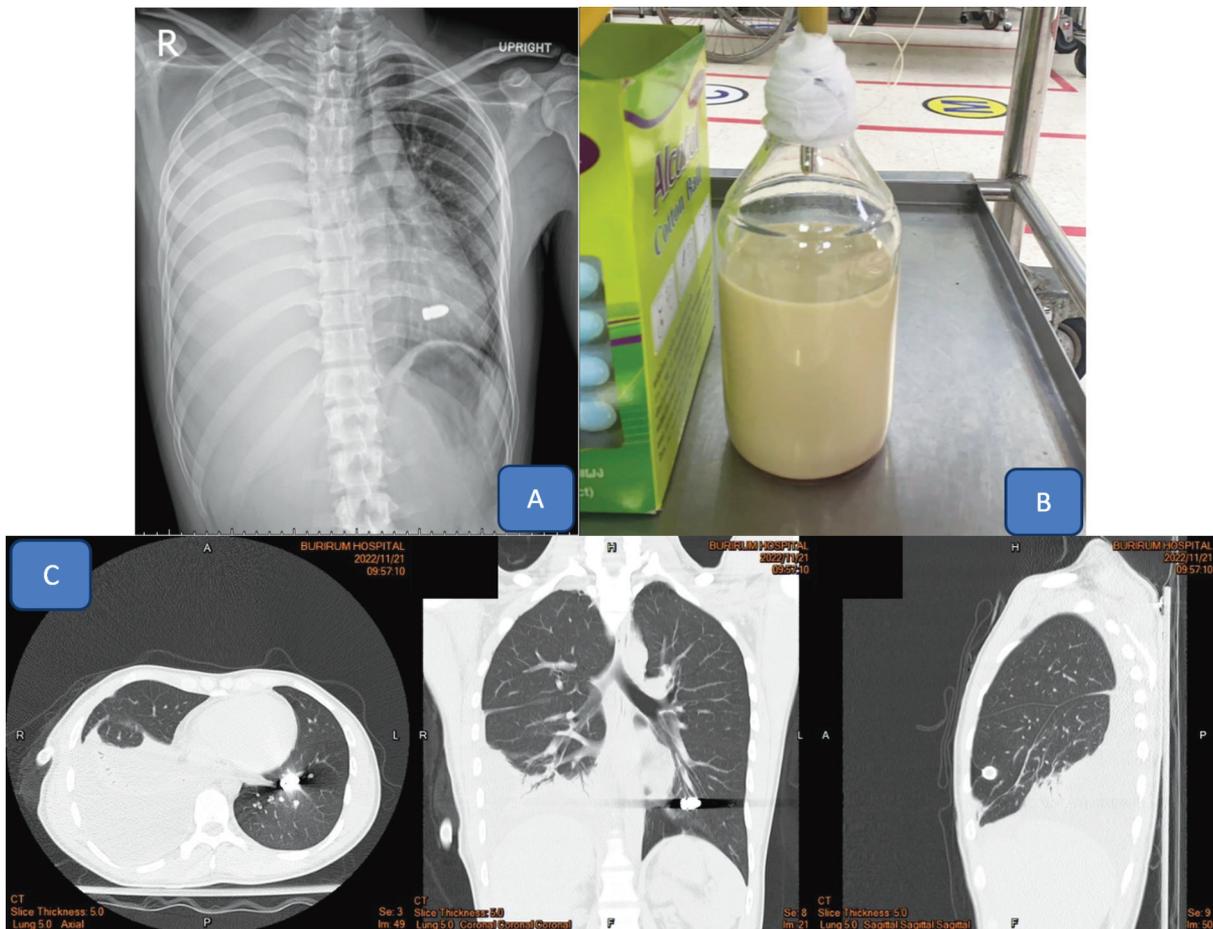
A: CXR on admission, B: Pleural fluid on admission, C: CT chest after on Rt. ICD
